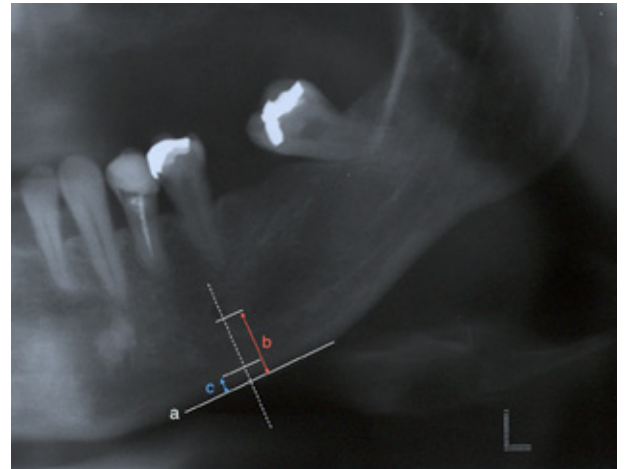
A cropped panoramic radiograph showing the PMI measurements (c/b). Lines a (parallel to the lower border of the mandible), b (distance between the bottom of the mental foramen and the base of the mandible, and c (cortical thickness).
